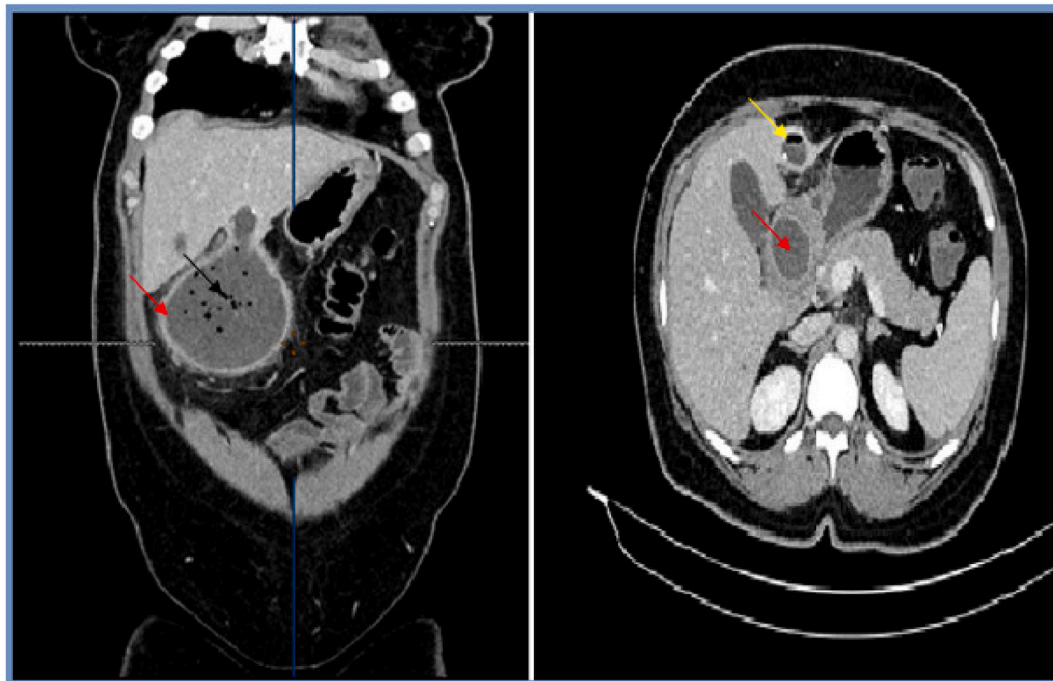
Different views of the CT scan of the patient's abdomen, showing a 2 cm multiseptal hydatid cyst in the segment III of the liver (yellow arrow) with an enormous exovesiculation (red arrow) communicating with the cyst and an air bubble sign (black arrow). (For interpretation of the references to colour in this figure legend, the reader is referred to the web version of this article.)
